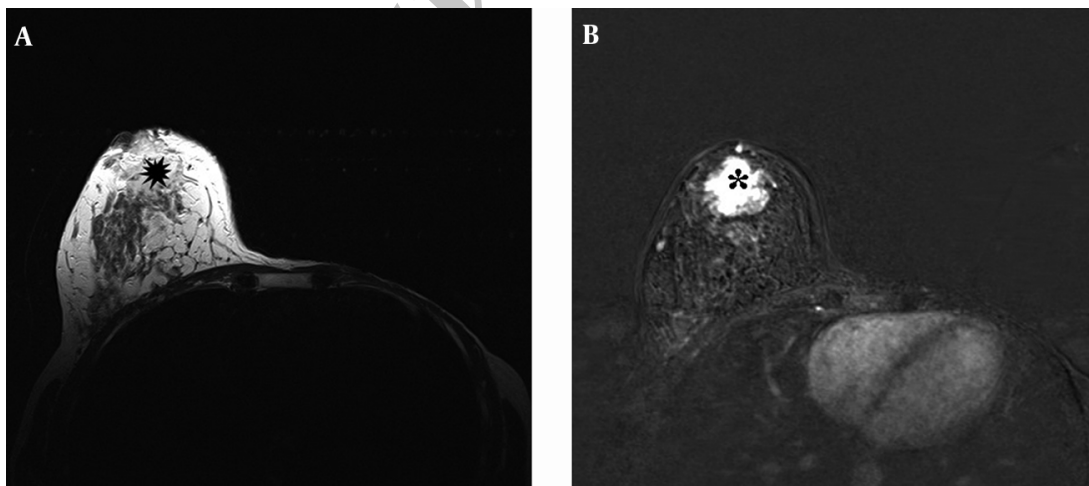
A, T2 weighted MRI showing hyperintense signal intensity of the lesion (black star) with irregular margins; B, Dynamic contrast-enhanced MRI shows early intense enhancement of the lesion (black star).
